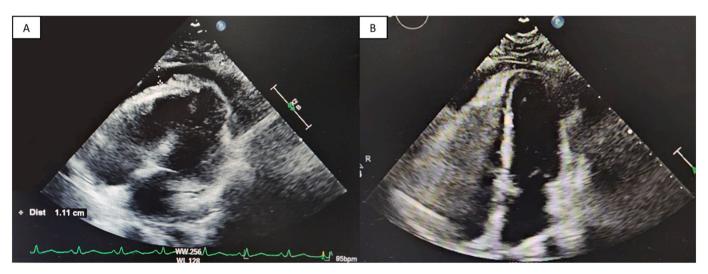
A. Transthoracic echocardiography Prior to treatment the distance between the outer border of the apex and pericardium showed a small to moderate pericardial effusion. B. Transesophageal echocardiography 2 days later demonstrated reduction of pericardial effusion.
